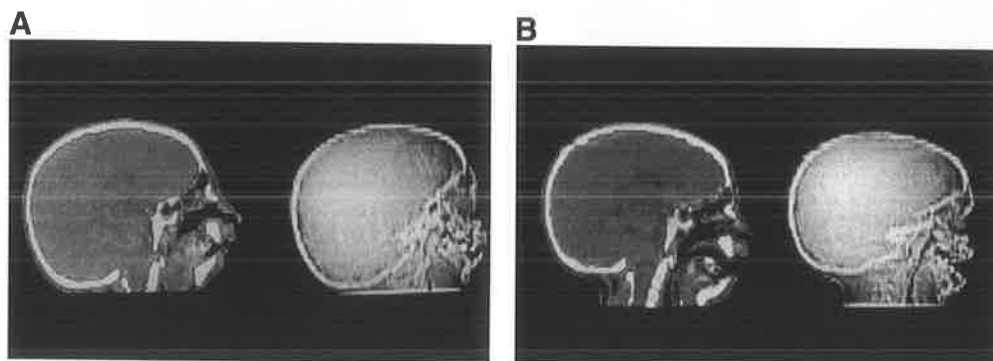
A. Preoperative sagittal two-dimensional computed tomography scan with outlining of the airway confirms obstruction of the retrotongue base pharynx. B. Comparable postoperative views identify the production of a patent retrotongue base pharyngeal airway.
